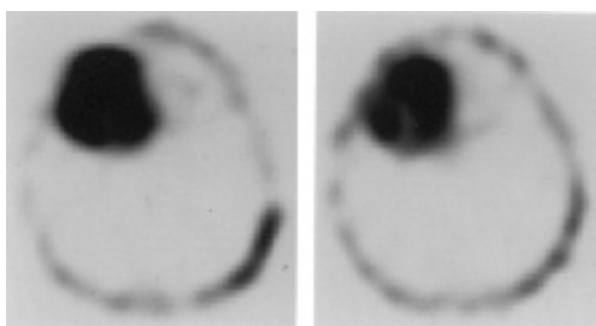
Tl-201 early (*left image*) and late (*right image*) brain SPECT in a 46-year-old man with malignant meningioma, 7.0 cm in diameter. The early uptake ratio (ER), the late uptake ratio (LR) and the ratio of LR to ER were 9.97, 6.03 and 0.60, respectively.
